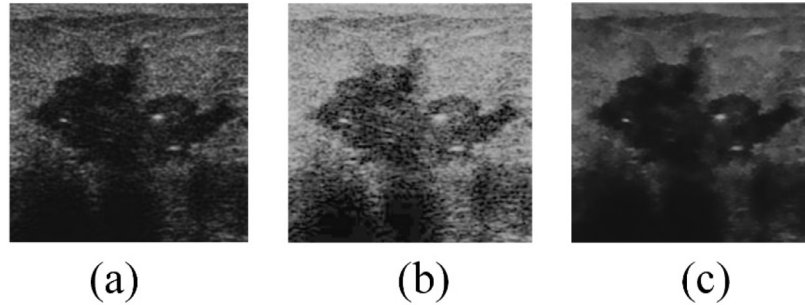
Fuzzy enhancement and bilateral filtering: (a) Original breast ultrasound image; (b) Fuzzy enhancement image; (c) Bilateral filtering image
